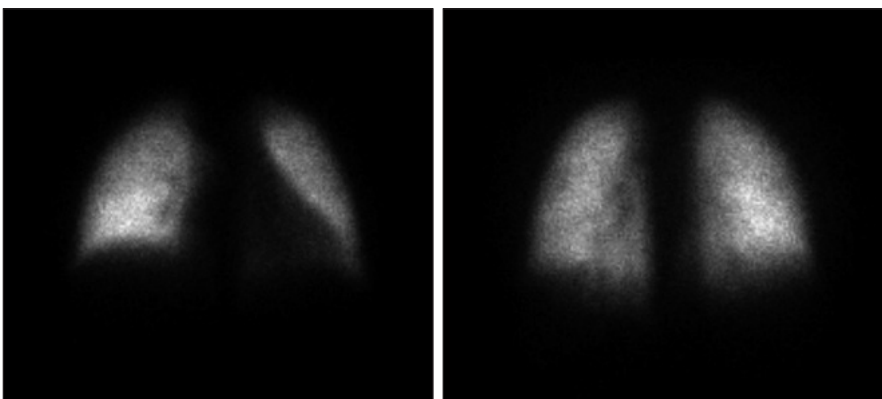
A patient with a normal scintigraphy imaging.
